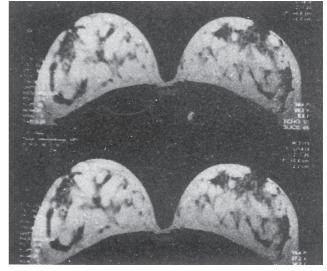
MRI shows normal breast, T_1 -and T_2 -weighted image
